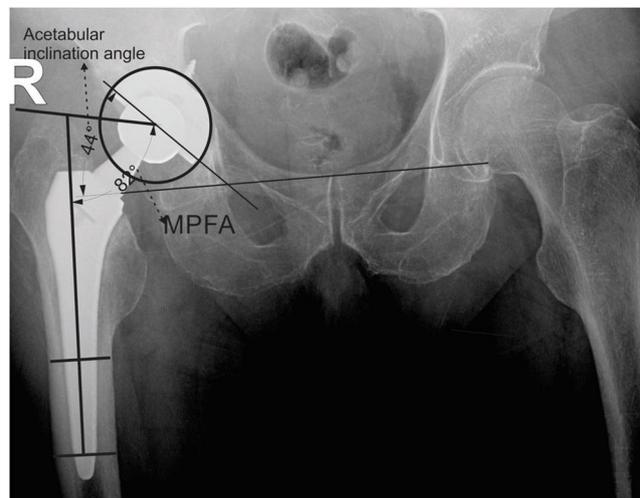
Measurement of acetabular inclination and MPFA on plain X-ray.
